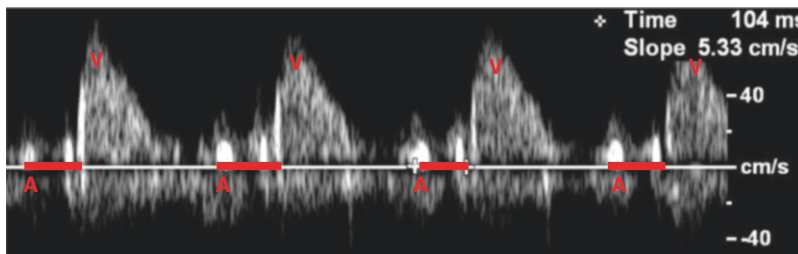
Pulse Doppler of SVC and aorta simultaneously. The “A” wave is seen representing atrial contraction followed by ventricular contraction (V). The red line represents the AV interval
